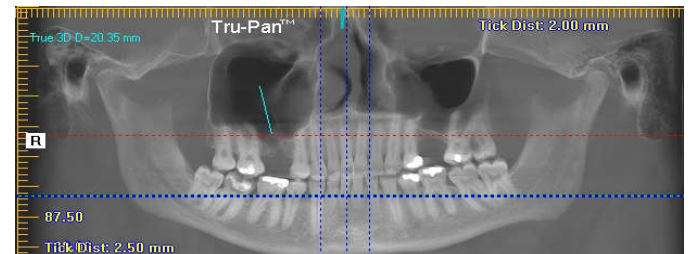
Panoramic reconstruction CBCT image showing osteo-sclerosis of the bone
